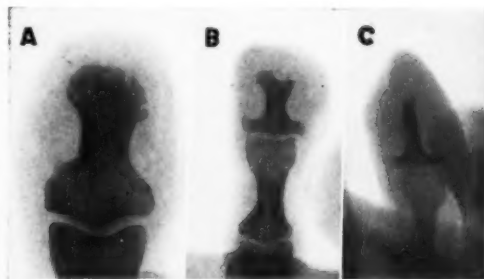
Case II: A. Left 1st toe. B. Left 2d toe. C. Left 4th toe. All three roentgenograms show various stages of atrophy.
